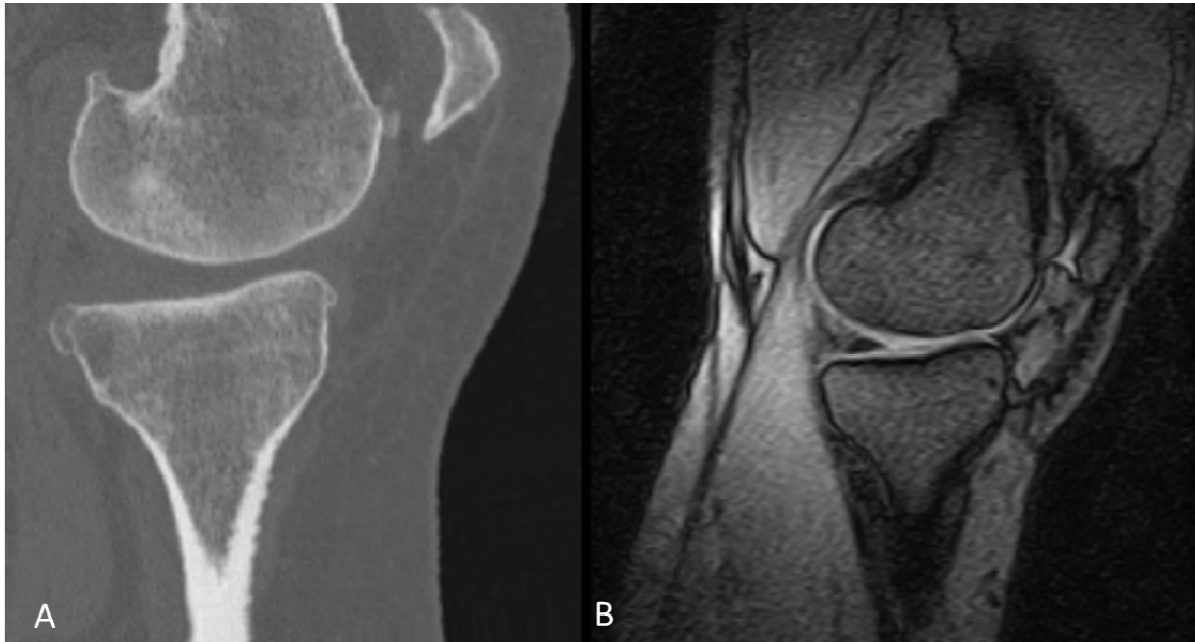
(A) Re-aligned CT image and (B) Standing MR image. CT images re-aligned such that the new alignment is similar to the standing MR images.
